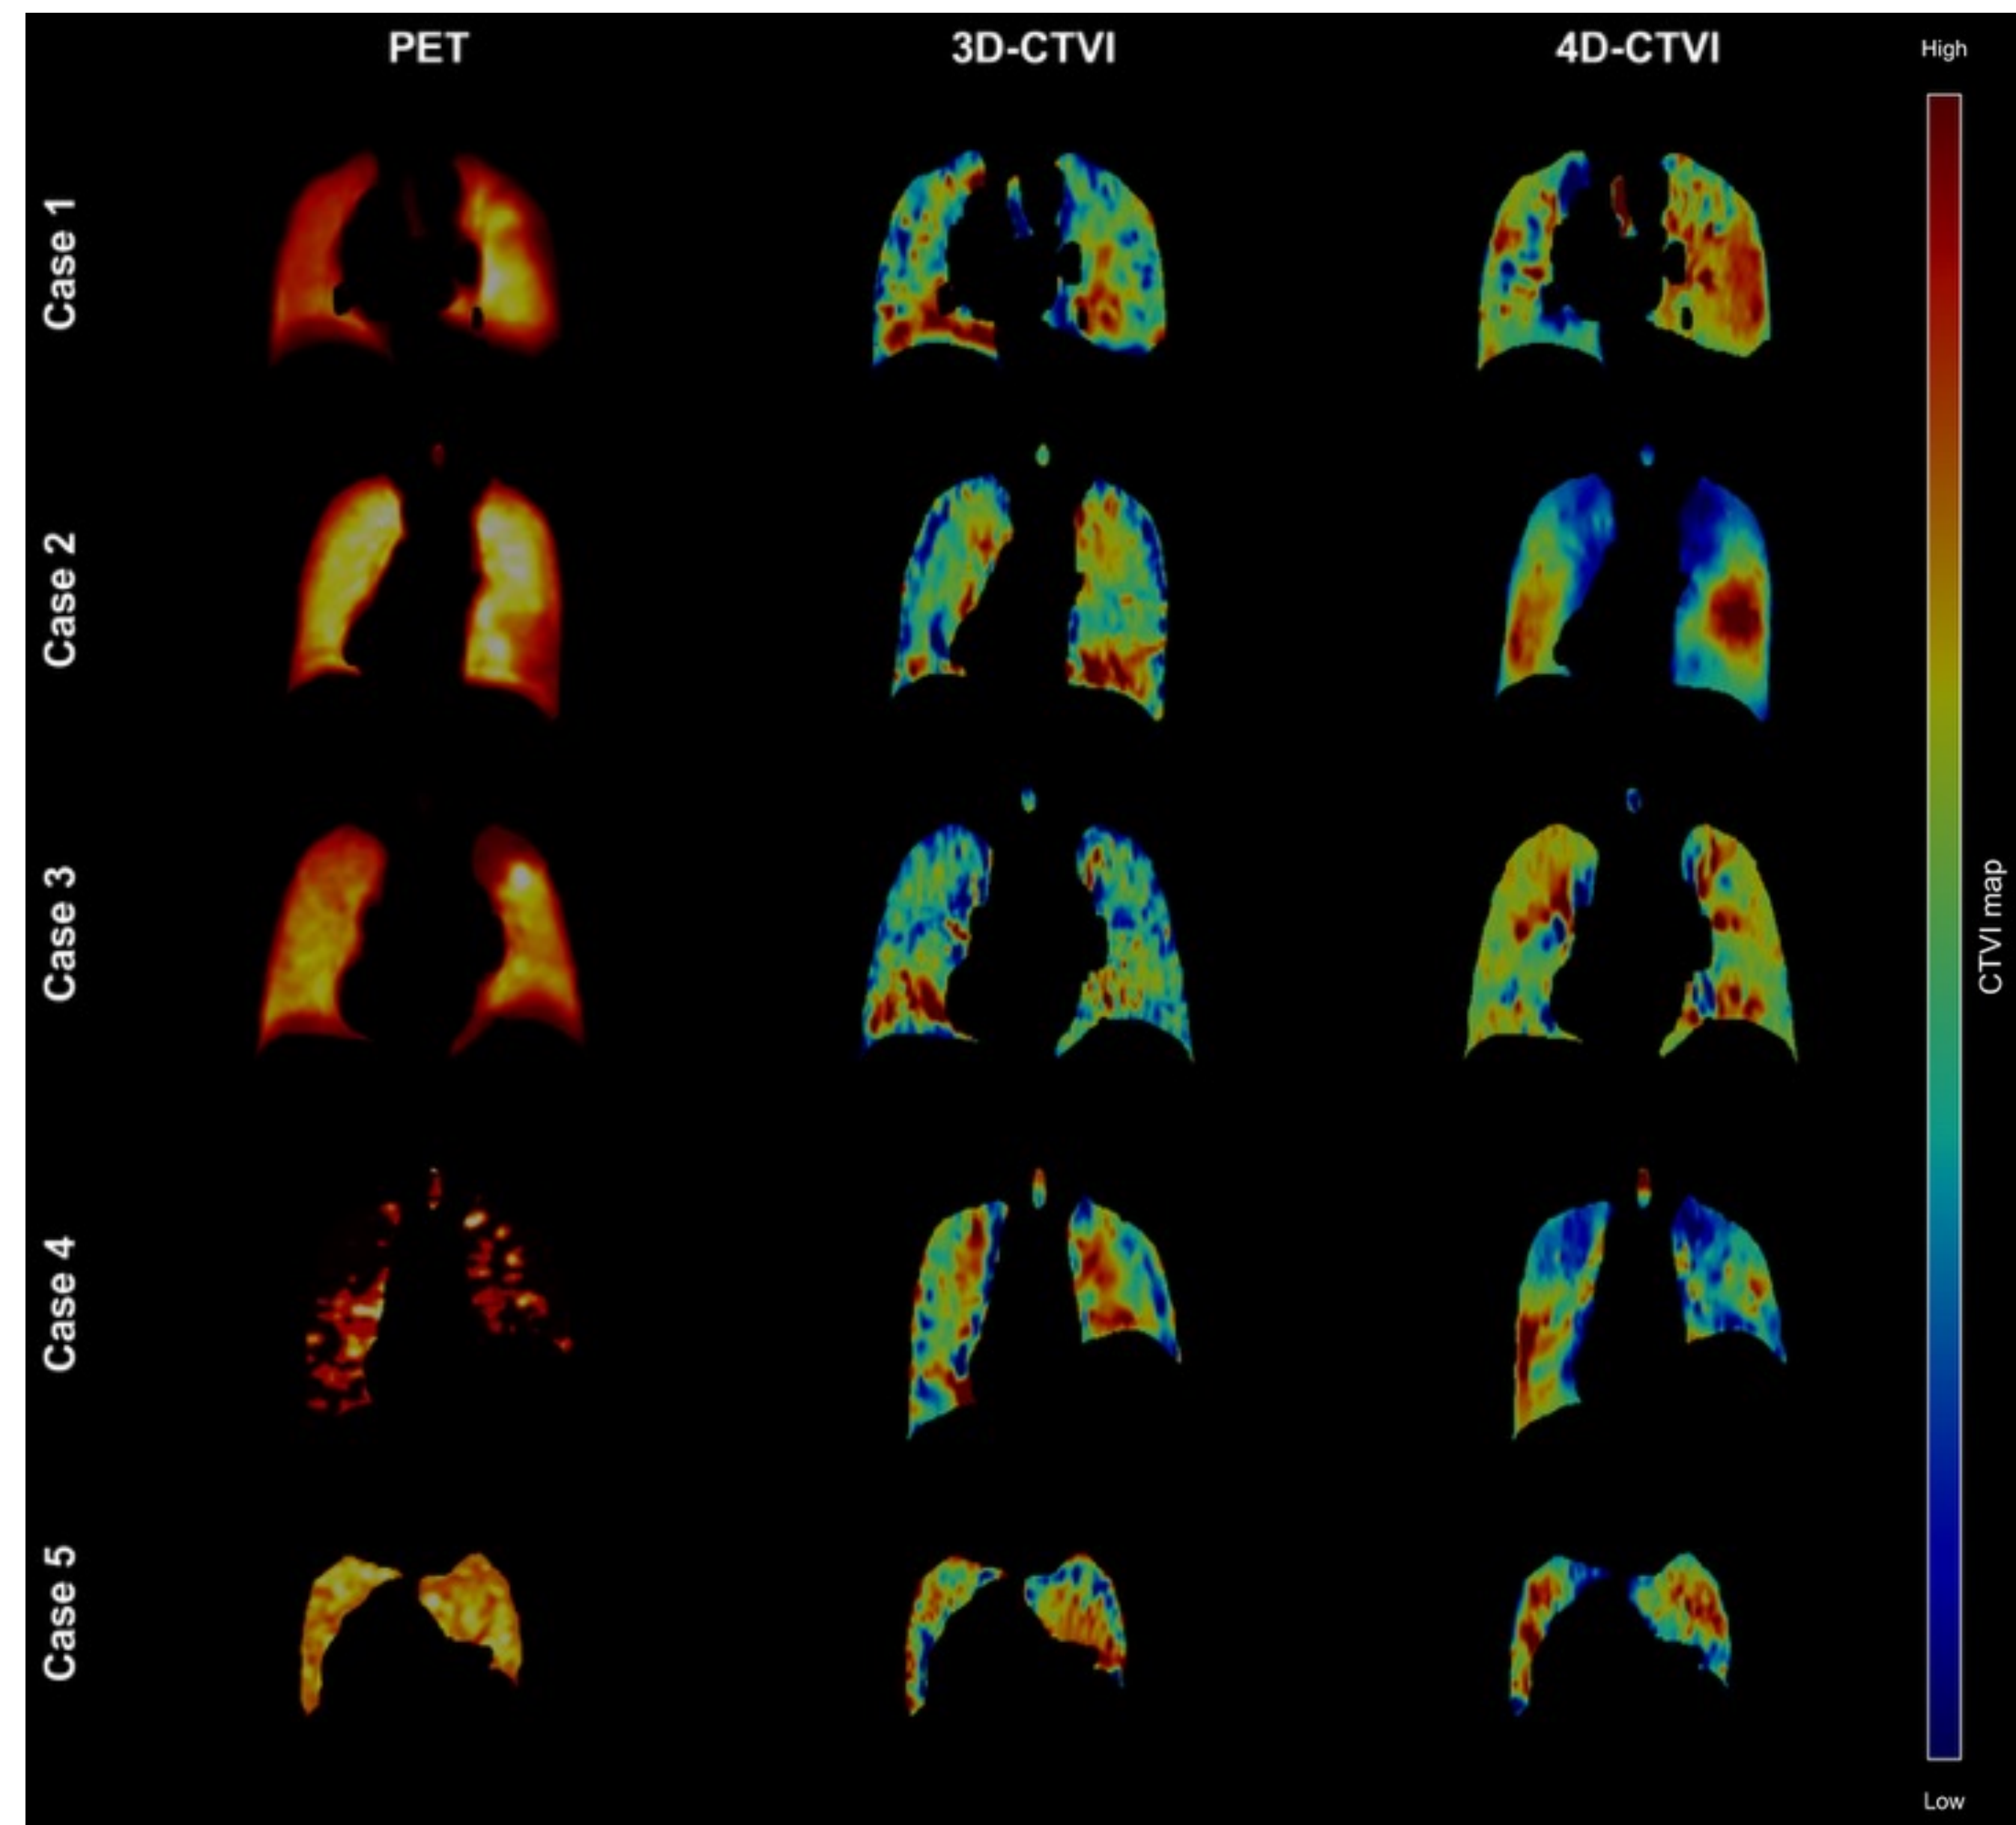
Visual comparison of CT-based ventilation imaging maps with Galligas PET.
